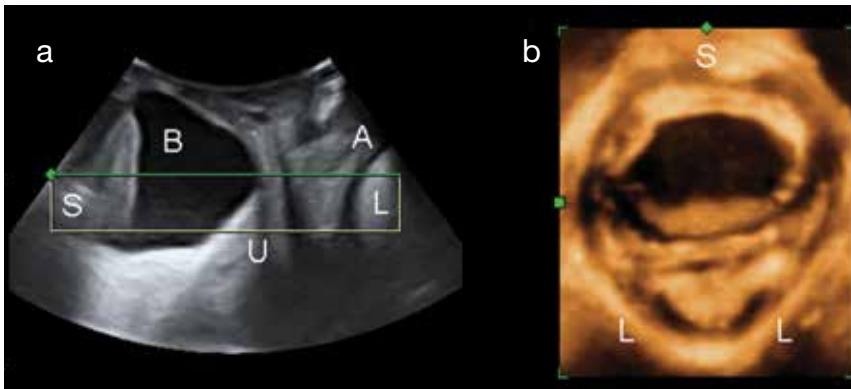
3D/4D perineal ultrasound demonstrating third-degree cystocele visible in the midsagittal plane (a) and marked levator hiatal ballooning in the axial plane (b). S = symphysis pubis; B = bladder; U = uterus; A = anal canal; L = levator ani.
